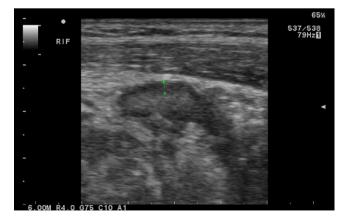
Abdominal ultrasound of the right iliac fossa demonstrating a thick walled tubular structure.
